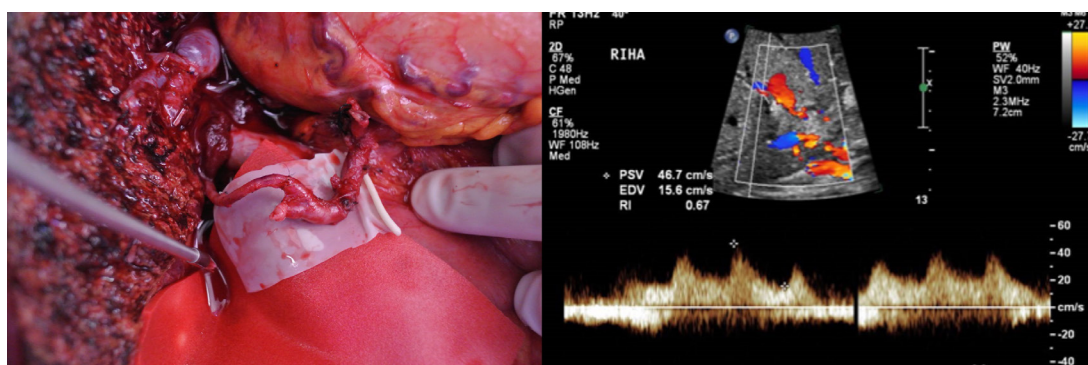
Living donor liver transplant in a patient with previous transarterial chemoembolisation and radiofrequency ablation. Left: Anastomotic thrombosis was salvaged with an interpositional radial artery graft on postoperative day 5. Right: Post-salvage ultrasonography showed good flow with a resistive index of 0.67.
